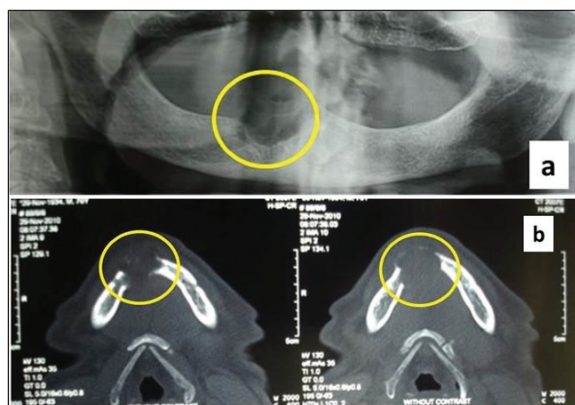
On X-ray examination of OPG (a) and CT Scan (b), the destructive expansive radiolucent lesion (3.5 x 3.0 cm) with well-defined border was seen on the right side of the mandible.
